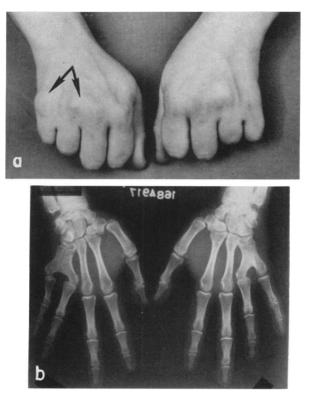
Hands of the grandson (V-26) of the propositus showing in his fist the closeness of knuckles 3 and 4 and the wide separation of 4 and 5 (arrows). The X-ray shows distal forking of the fused metacarpals 4 and 5 with lateral deviation of the right ring finger as well as the fifth.
